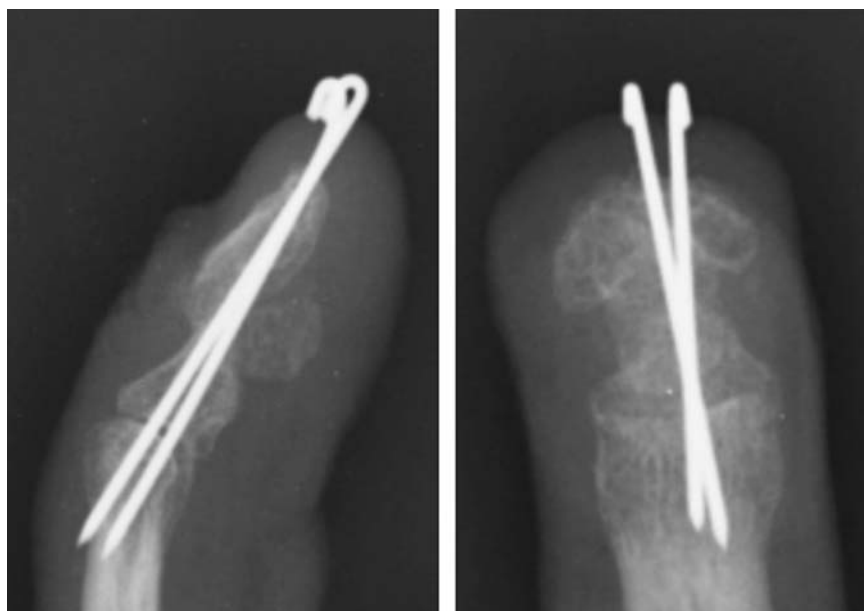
Bone graft and fixation with K wires through the DIP joint. This x-ray is showing the consolidation of the nonunion at 6 weeks after the first operation.
